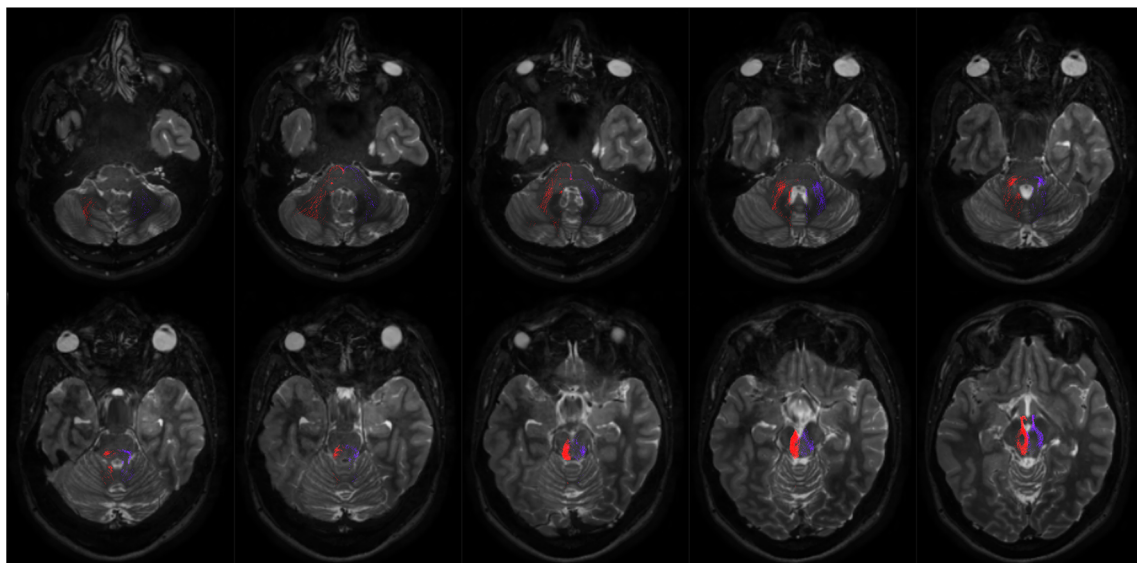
Course of ipsilateral cerebellar cortex-mammillary connections. Ten axial T2-weighted images show the course of the connections between the cerebellar cortex and mammillary bodies. On the right side, fibers are red colored and, on the left side, blue colored. The first row
